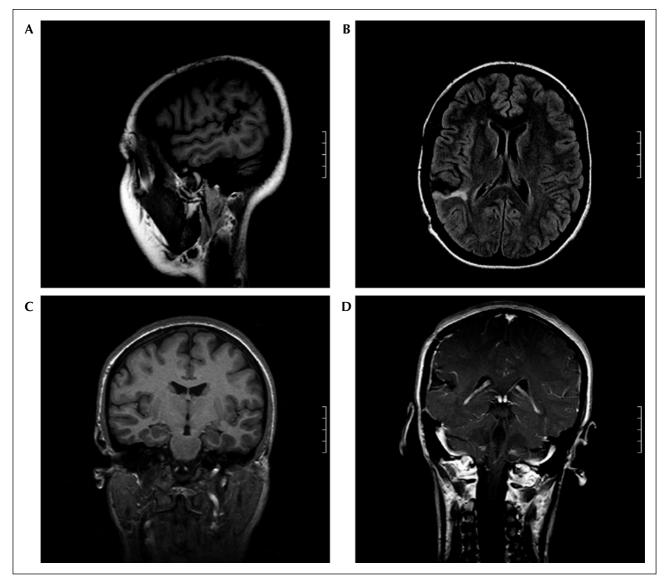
Sagittal T1, axial FLAIR, and coronal enhanced brain MRI showing limited lesionectomy.
